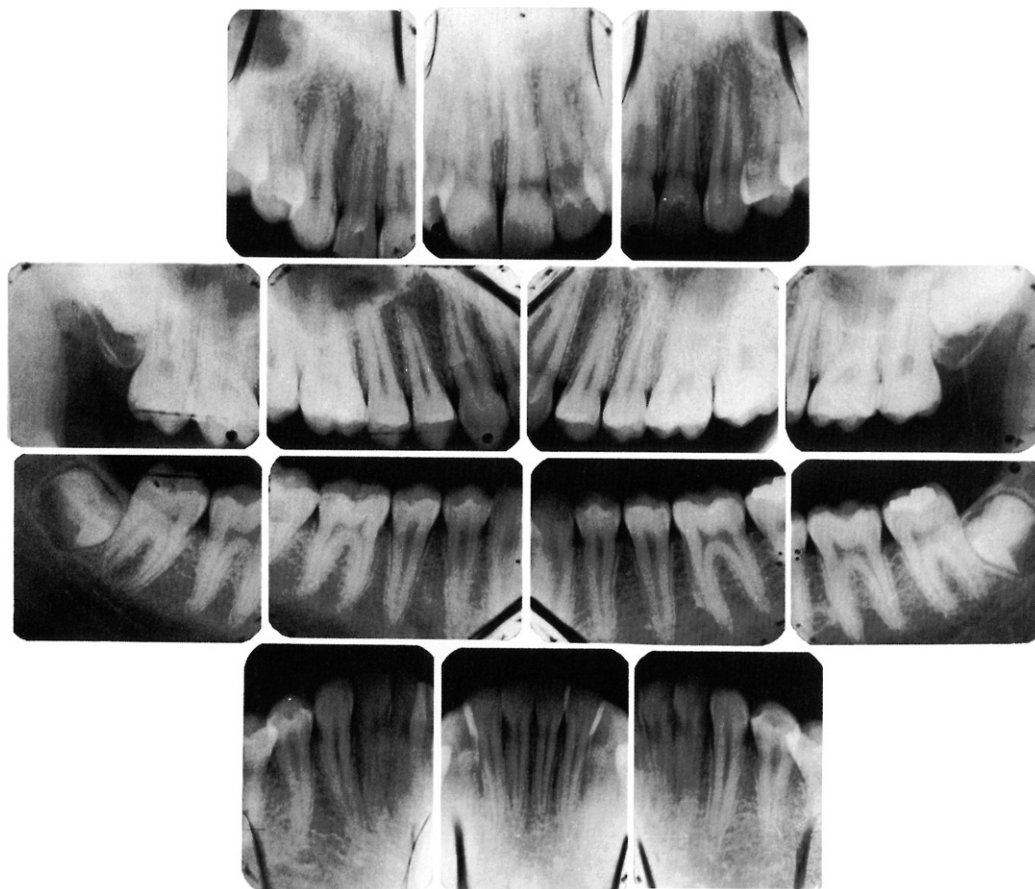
Radiograph demonstrating form of alveolar crest, contact areas, and relation to form of the crown.
